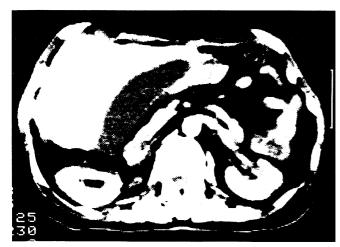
Percutaneous cholecystostomy: A: Acute cholecystitis demonstrated on CT-scan: distended gall-bladder, thickened wall and fluid collection around the gallbladder.
